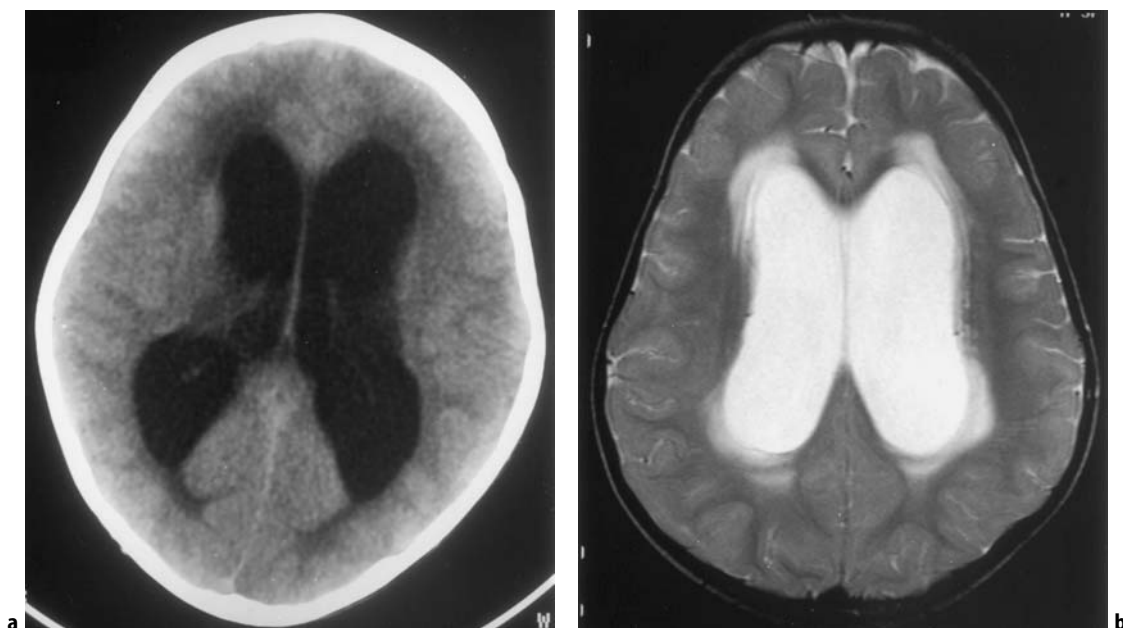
The imaging characteristics of trans-ependymal seepage of CSF in hydrocephalus. On CT, a rim of low density and on MRI, a rim of high-signal intensity on the T2-weighted image.
